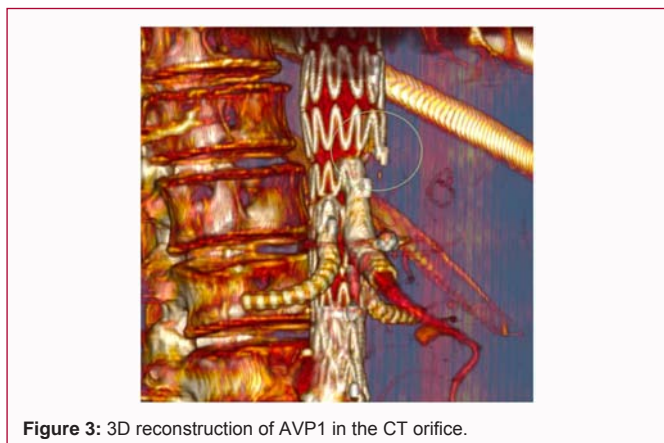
3D reconstruction of AVP1 in the CT orifice.
